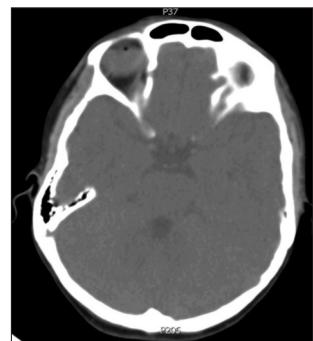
Negative computed tomography findings of cavernous sinus
